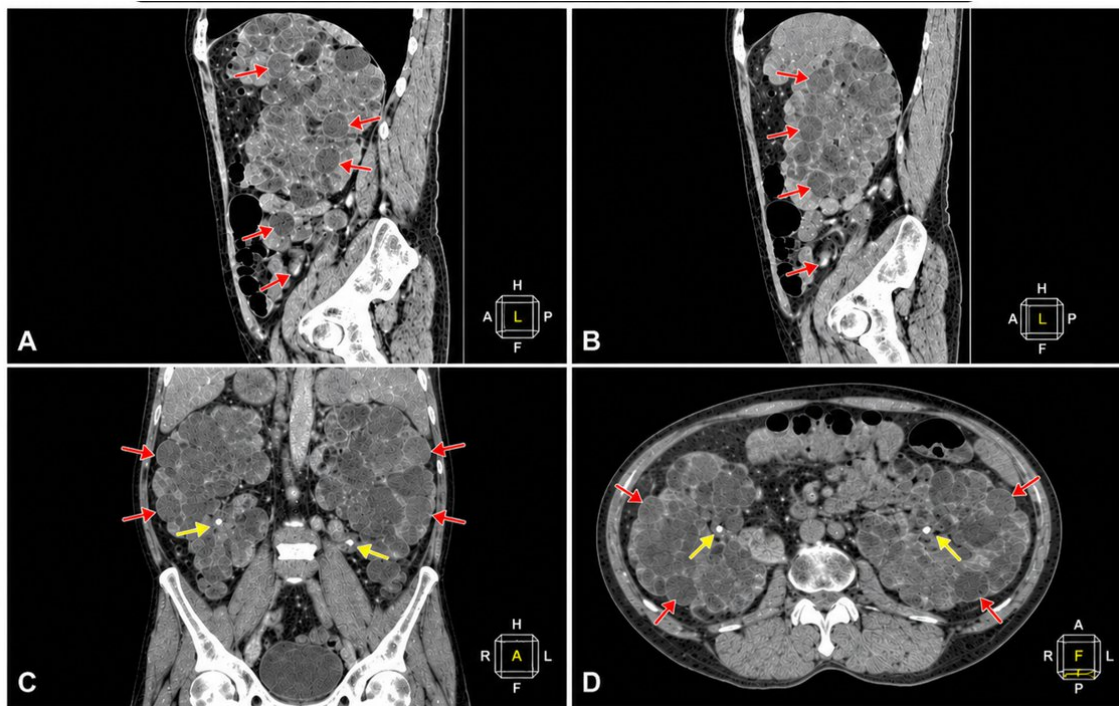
CT Scan (sagittal, coronal, and axial image)
